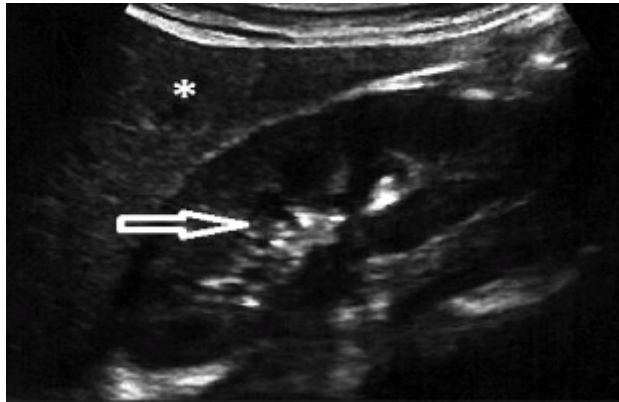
The abdominal ultrasound (longitudinal section) displays the right kidney with normal renal cortical echogenicity, graded as Grade 0. This indicates echogenicity less than that of the liver (marked with a star), while maintaining preserved corticomedullary definition (indicated by an arrow).
